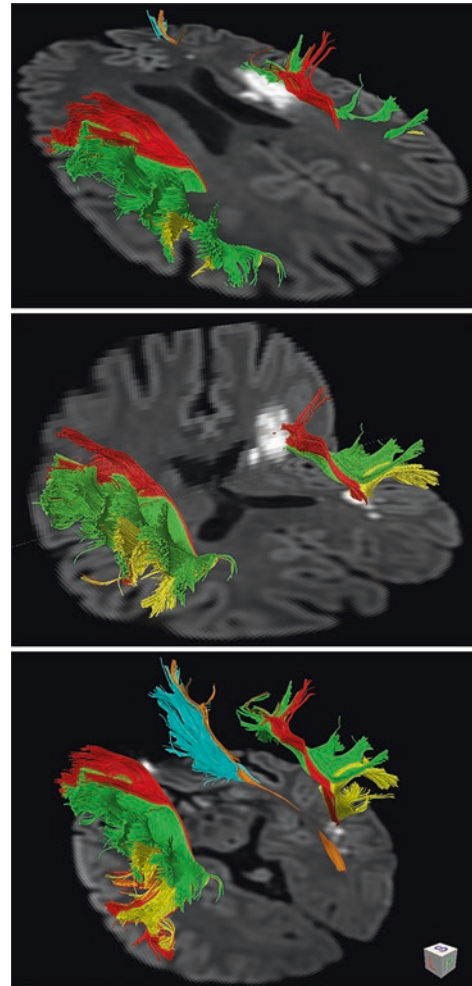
Fifty-five years-old right-handed male presenting with acute onset of severe left visual neglect and left hemiparesis. MR DWI showed small multiple acute ischemic infarcts in the right cerebral WM and no evidence of infarcts in GM. DTI tractography was instrumental to accurately localize one infarct to the SLF-III (green) that is a component of the large-scale networks controlling visuospatial attention. Another infarct was localized in the stem of the AF (AF-direct in red, AF-posterior segment in yellow); the IFOF (orange) and UF (cyan) were not involved. This case report supports the hypothesis that neglect may result from disruption of a distributed attention network (Ciaraffa et al. 2012)
